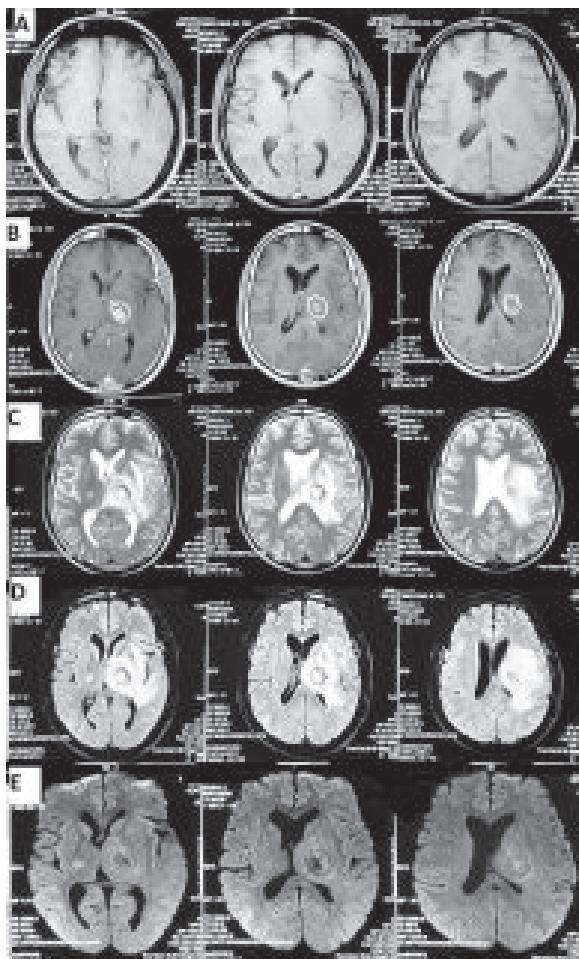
MRI of brain of the patient. A: T1 weighted image, B: T1 post contrast, C: T2 weighted image, D: T2 FLAIR image, E: Diffusion weighted image
